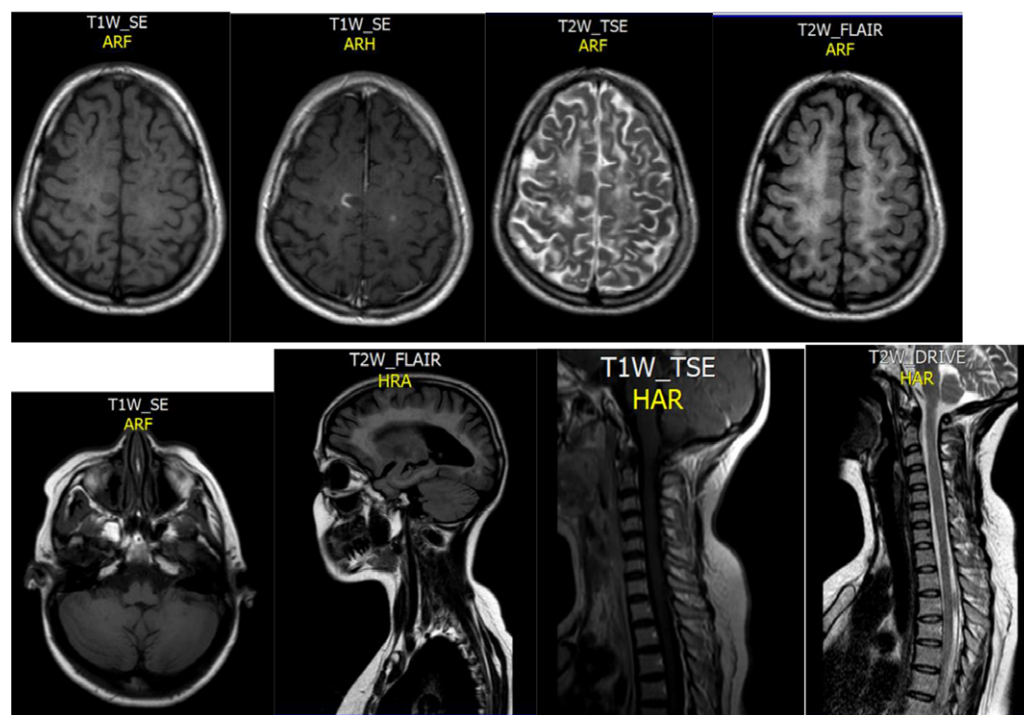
The brain and cervical spine MRI in March 2023 showed diffuse supratentorial white matter abnormalities with high signal intensity and severe volume loss, along with multiple supratentorial white matter lesions, some of which showed incomplete ring enhancement. Regarding the cord, there were patchy signal abnormalities with cord atrophic changes. Overall findings are suggestive of an advanced white matter disorder involving the brain, brainstem and cord.
